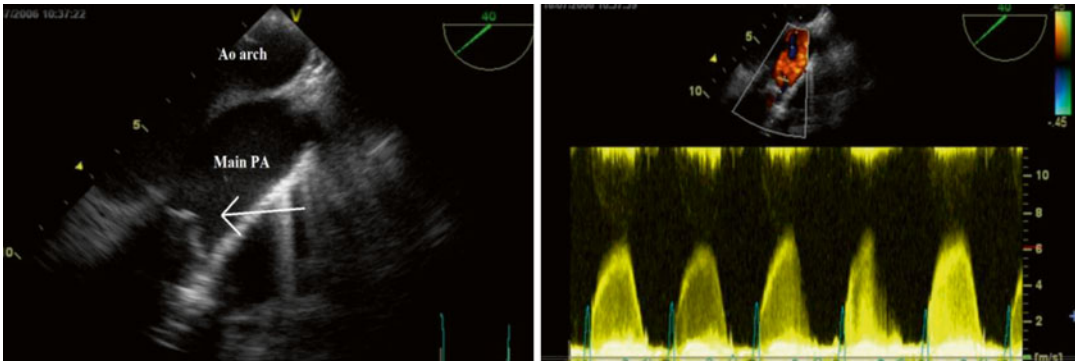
CW Doppler study showing the maximum velocity which is obtained during TEE arch view. *Main PA* main pulmonary artery, *AO arch* aortic arch
